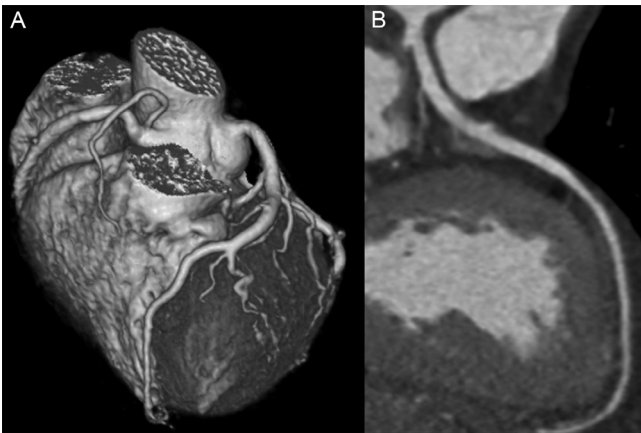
CT coronary angiography performed with the high pitch spiral scan protocol. Male, 58 years old, presenting with stable angina pectoris. Mean heart rate during the scan 54 beats per minute. Optimal image quality in all segments. Estimated radiation dose 0.67 mSv (tube voltage 100 kV). Volume Rendered Technique (VRT) image (A) revealing the anatomy of the coronary tree. Curved Multiplanar reformatting image (cMPR) of the LAD (B) showing a calcified obstructive lesion in the proximal part of the vessel.
